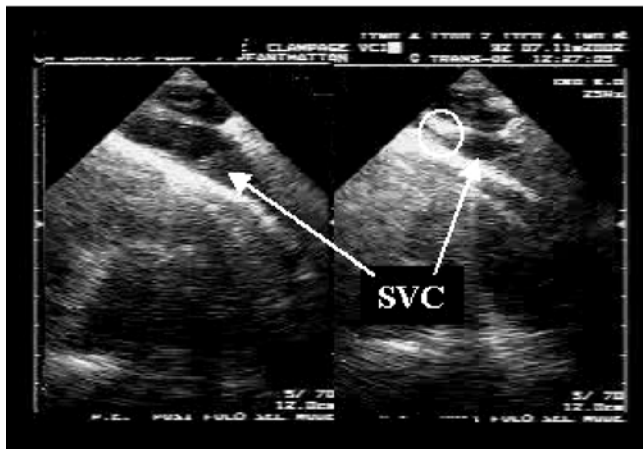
Superior vena cava (SVC) in a long-axis view at transesophageal echocardiography. Note that tidal ventilation induced a partial collapse in just a narrow portion of the vessel (*circle*). *EXPI* expiration, *INSPI* insufflation
